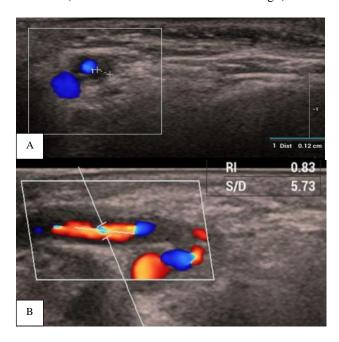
(A and B): Superficial temporal artery doppler-wall thickening with hypoechoic halo (halo sign) and luminal narrowing in bilateral superficial temporal arteries.
